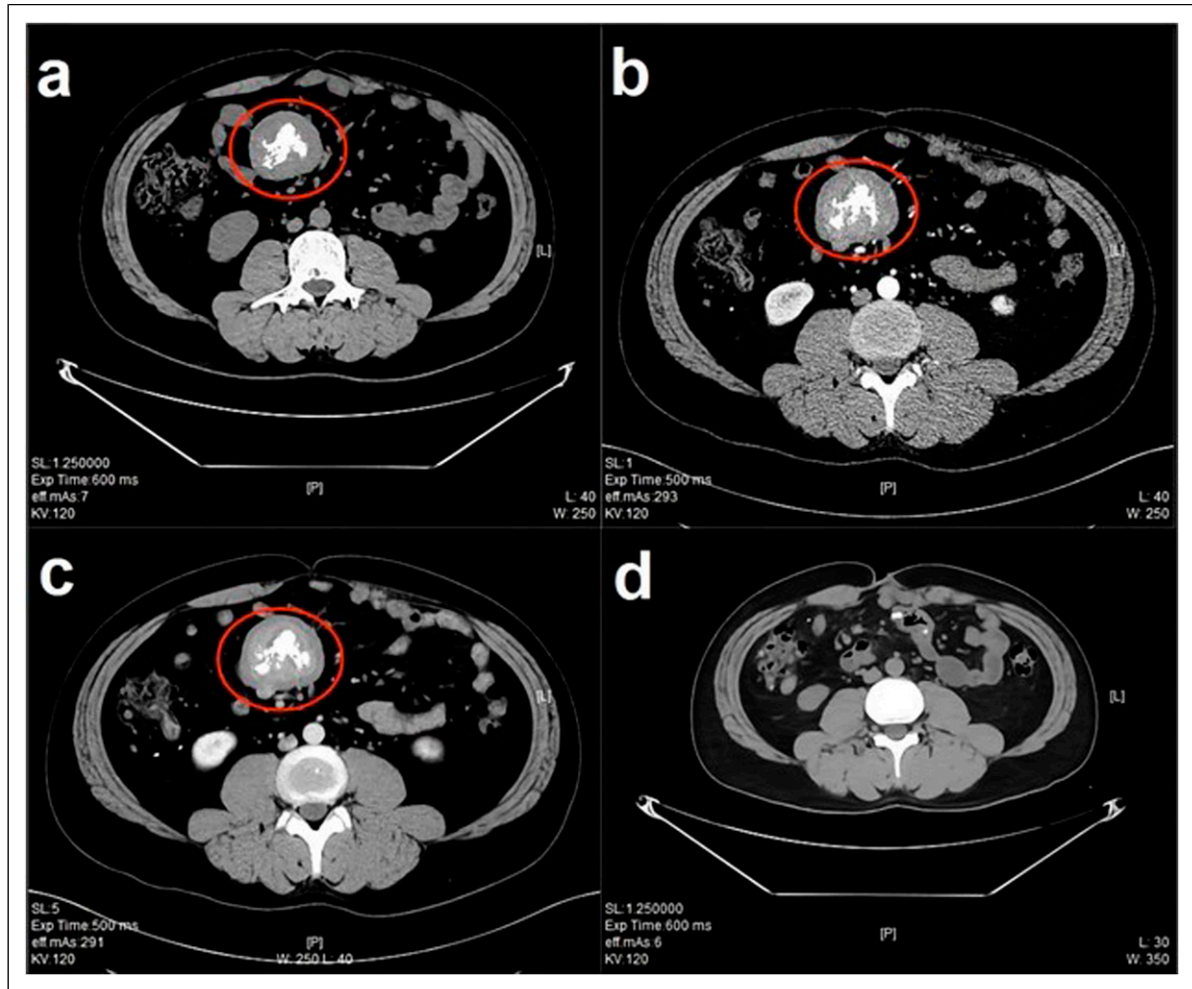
The computed tomography (CT) imaging of the patient. (a) The CT scan shows a sharply demarcated mass with branching calcification shadows inside. (b) Slight enhancement at the arterial phase. (c) Persistent enhancement at the vein phase. (d) CT re-examination after 2 years showed no enlarged mass or lymph nodes.
